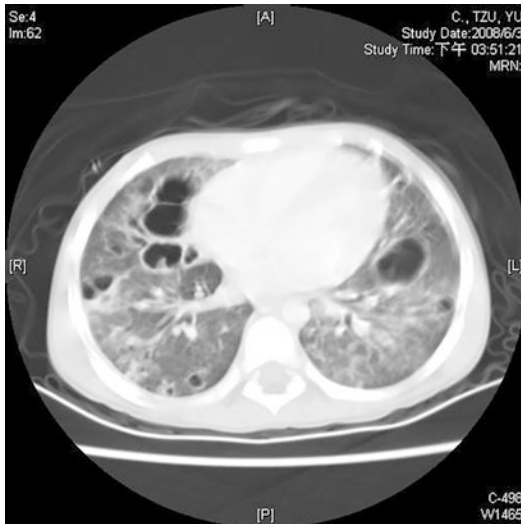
High-resolution computed tomography (HRCT) revealed multiple cystic lesions with ground glass appearance in both lung fields
